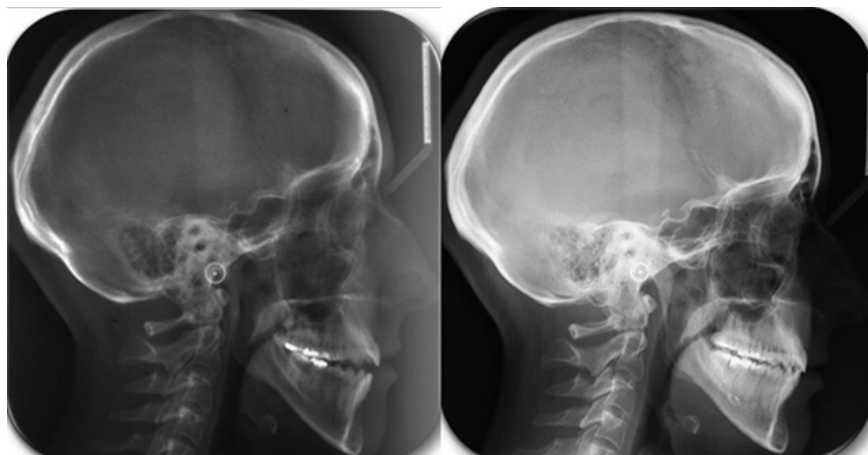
Pre-treatment and post-treatment lateral cephalometric radiographs.
